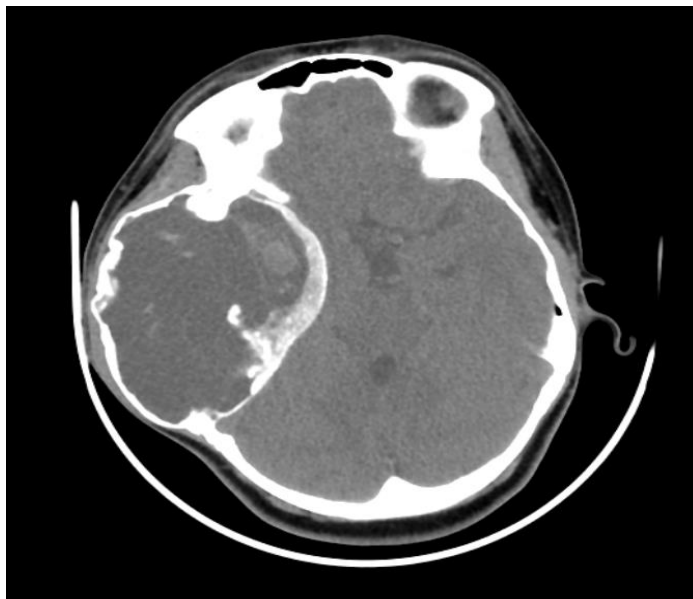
A bone window of CT scan of Right temporal ABC
